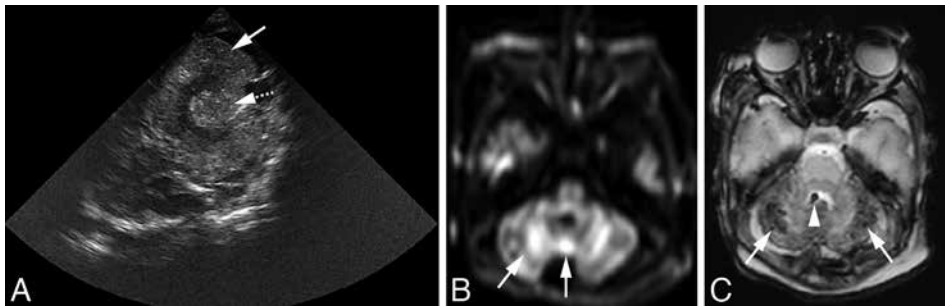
(A) Axial ultrasound scan in full-term neonate (gestational age 37 weeks, severe HIE) performed on 2nd day of life, using the MF as acoustic window, demonstrating abnormal echogenicity of the cerebellar vermis (dotted arrow) and both cerebellar hemispheres (arrow). (B) and (C) MRI in same neonate on 3rd day of life showing a combination of ischemic and hemorrhagic injury. Diffusion-weighted imaging (B) showing abnormal signal intensity in cerebellar vermis and hemispheres (arrows). T₂* FFE scan (C) showing multiple small hemorrhages in both hemispheres (arrows) and in the fourth ventricle (arrowhead).
